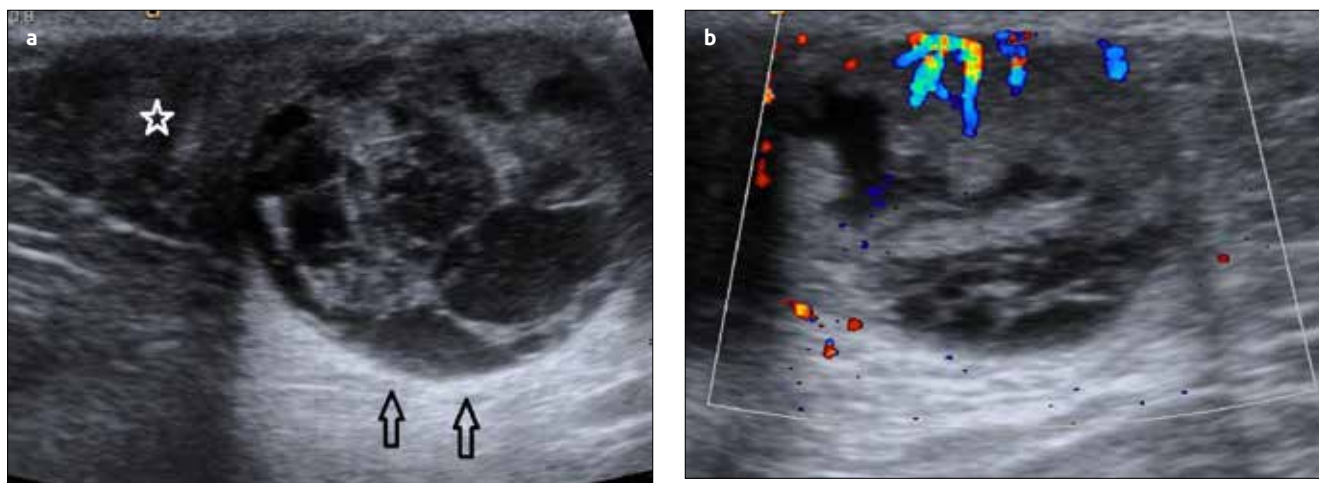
(a-b). US demonstrated hypoechoic glandular structure compatible with gynecomastia (star) and well-circumscribed mass shows predominantly cystic with solid components-thick septations that evaluated as complex lesion. Posterior acoustic enhancement was seen (stars) (a). On Doppler US, blood flow was seen in the solid components (b)
